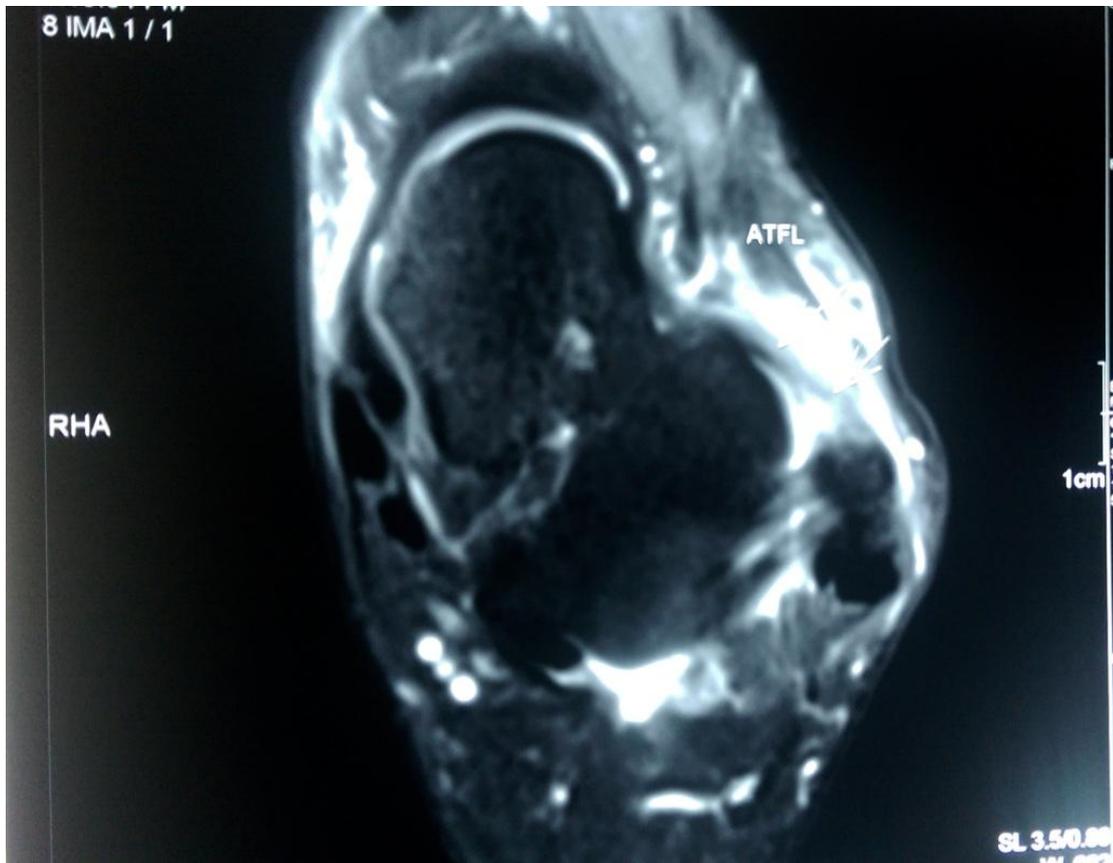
MRI depicting a complete tear of the ATFL
